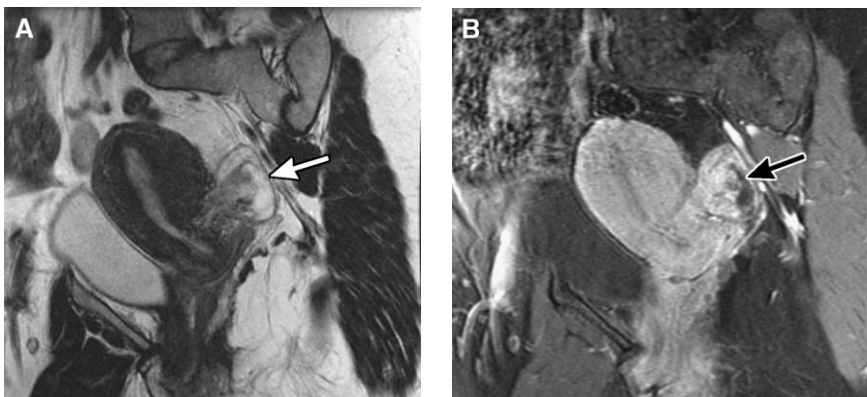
(A) Sagittal T2-weighted scan demonstrates a primarily hyperintense mass arising from the lower corpus/upper cervix (*arrow*). (B) Sagittal T1-weighted scan after intravenous gadolinium demonstrates a pattern of enhancement that is indicative of myxomatous degeneration of a myoma.
